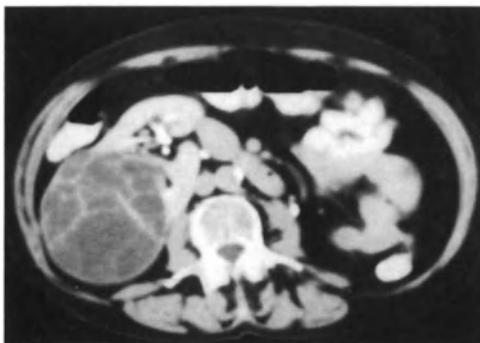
Benign multilocular cystic nephroma. Contrast CT scan shows an encapsulated right renal mass containing numerous septations and cystic locules of differing sizes. (Courtesy of R. Dyer and J. Caldemeyer, reprinted with permission from Grune and Stratton, Inc. publishers of Benign space-occupying conditions of the kidneys, Semin Roentgenol 1987; 22: 275-283, Fig. 5, p 281.)
